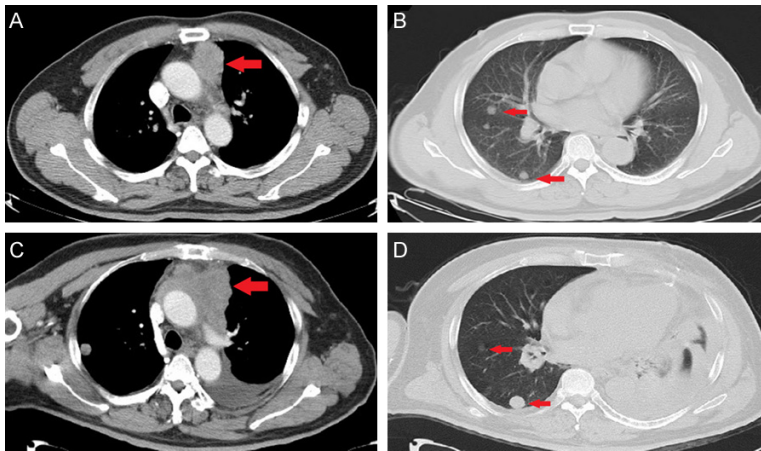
Computed tomography (CT) scans in case 6. A. CT scans showed a 4.6*3.3 cm mass (arrow) at anterior superior mediastinum at diagnosis. B. Multiple nodules (arrow) in both lungs at diagnosis. C. CT scans showed disease progression of pleural effusion in left lung and tumors mass (arrow) increased of anterior superior mediastinum after first line chemotherapy treatment. D. Multiple nodules in both lungs (arrow) after first line chemotherapy treatment.
